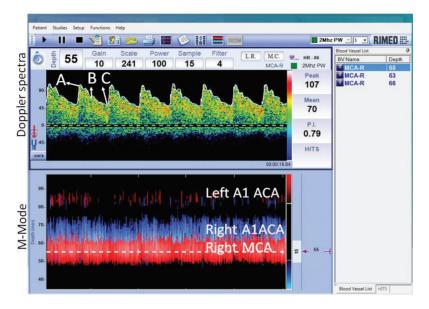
Normal TCD spectra. Doppler spectra on the upper panel represent the flow characteristics from the depth of 55 mm. The lower panel represents the M-mode, which shows the flow signals from all the intracranial arteries that lie between 35 and 95 mm of the ultrasound beam. Red signifies the flow toward the probe, while blue shows the flow away from the probe. The lower broad signal in red between 46 and 64 mm shows the flow in the right middle cerebral artery (MCA). The blue signal between the depths of 64-73 mm is obtained from the ipsilateral A1 segment of ipsilateral anterior cerebral artery (ACA). The faint red signal at the top of the M-mode panel represents flow in the contralateral A1 ACA.
